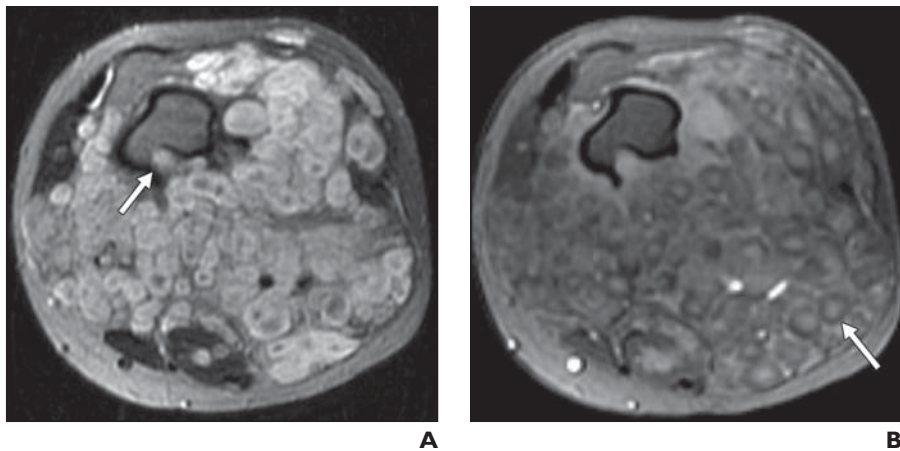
17-year-old girl with neurofibromatosis type 1 and plexiform neurofibroma of left thigh. A, Transverse T2-weighted MR image shows multinodular confluent mass with multiple target signs encasing femur. Note mass effect and endosteal scalloping along posterior aspect of femur (*arrow*). B, Transverse fat-suppressed T1-weighted MR image obtained after IV administration of gadolinium chelate shows variable enhancement of plexiform neurofibroma with multiple “reverse target” signs (*arrow*).
